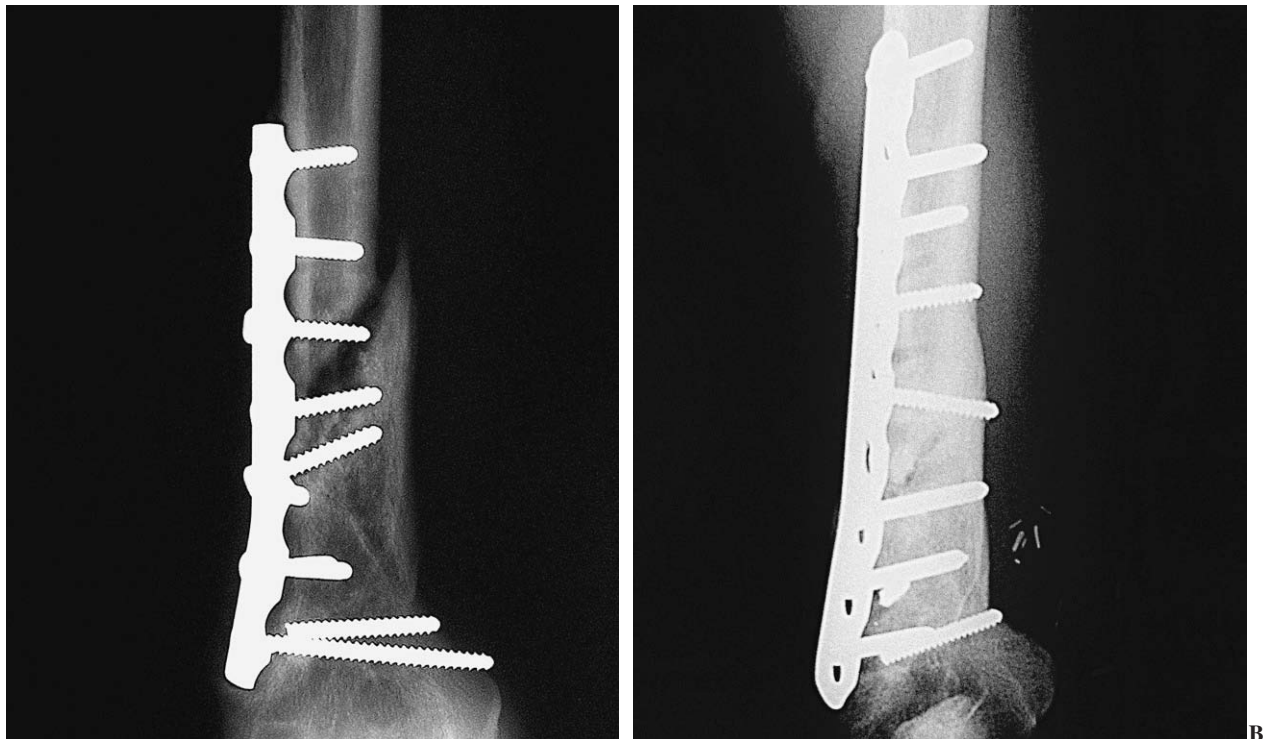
Case 4. Pre-surgical X-ray of a recalcitrant nonunion in the distal humerus (A). A butterfly-shaped fragment has consolidated in the distal region, but the proximal region has not consolidated after two attempts to change the hardware and bone grafting. X-ray taken 3 months after microvascular flap placement (B). The result was satisfactory.
